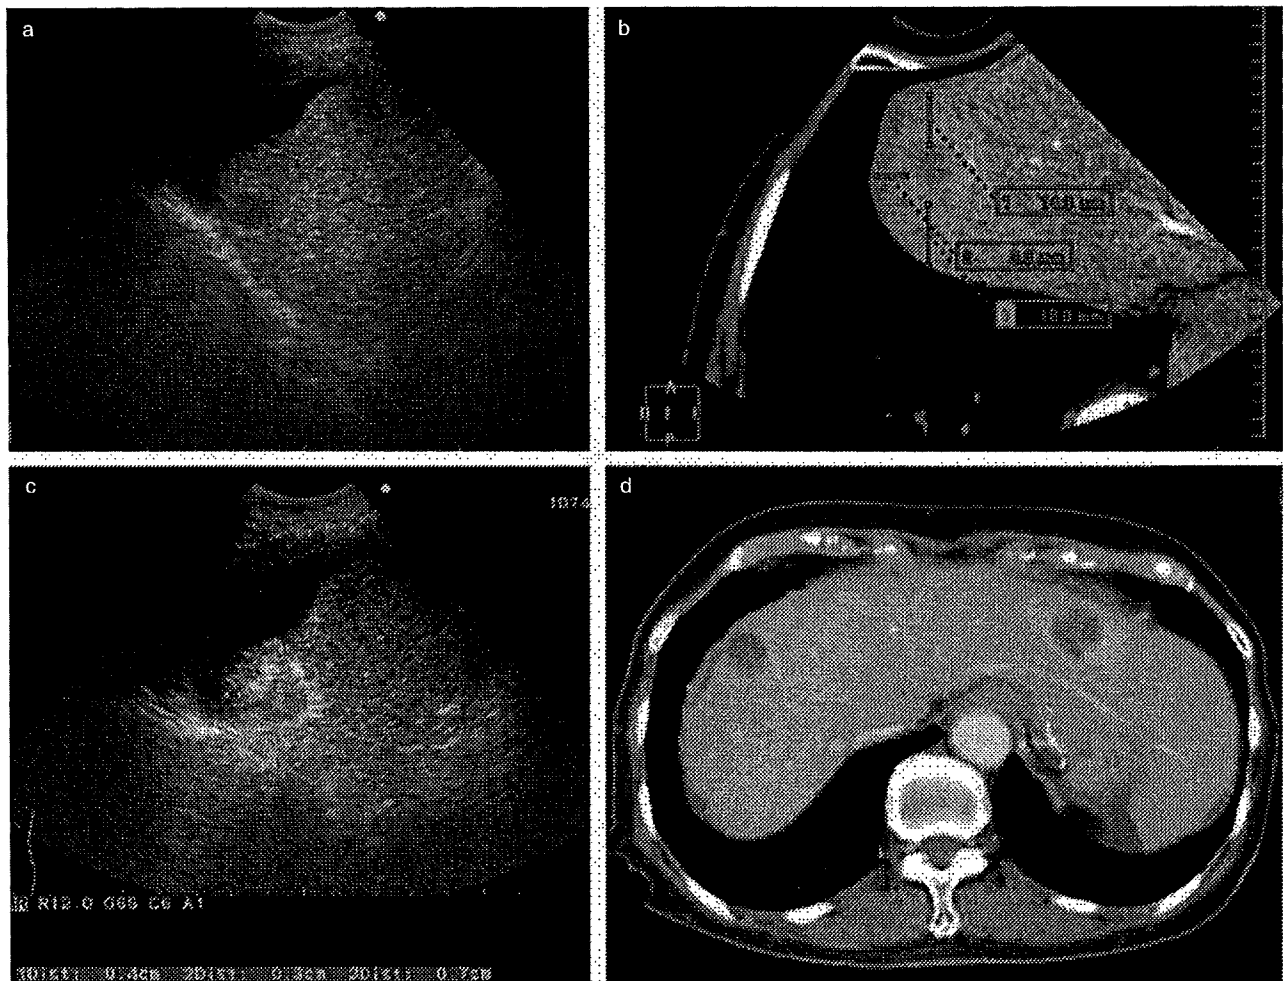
Clinical experience using the hyperechoic rim. (a) The tumor is located in the hepatic dome. (b) The computed tomography virtual ultrasound image prior to radiofrequency ablation. (c) By referencing (b), the hyperechoic rim can be seen to surround the tumor. (d) Computed tomography images obtained after radiofrequency ablation show that an adequate safety margin was achieved.
